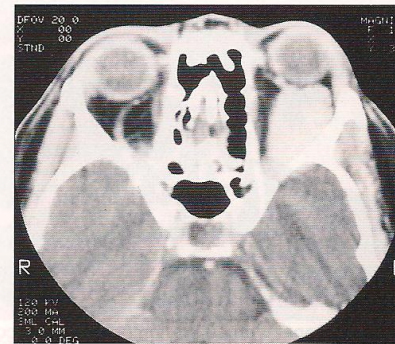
Axial computed tomogram of the same patient with contrast enhancement during Valsalva maneuver. Note that the enhancing orbital mass now is more prominent.
